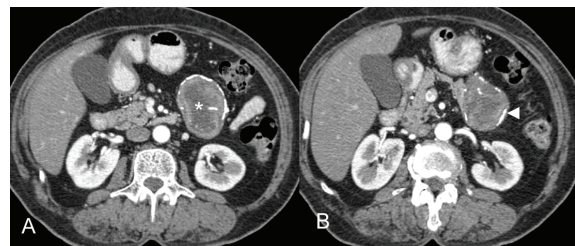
A 62 year-old female with history of chronic dyspepsia. Axial post contrast CT scan (A, B) show solid and cystic mass with heterogeneous enhancement (*) at tail of pancreas with partially peripheral calcification (arrow head). Pathology reveal solid pseudopapillary tumor
